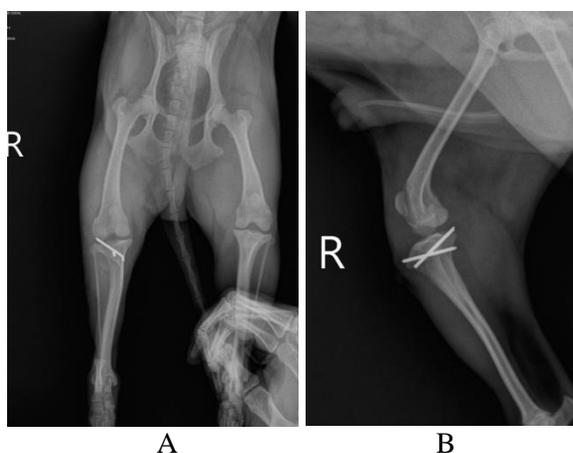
Post operative radiographic evaluation. (A) Antero-posterior, (B) medio-lateral radiographs.
